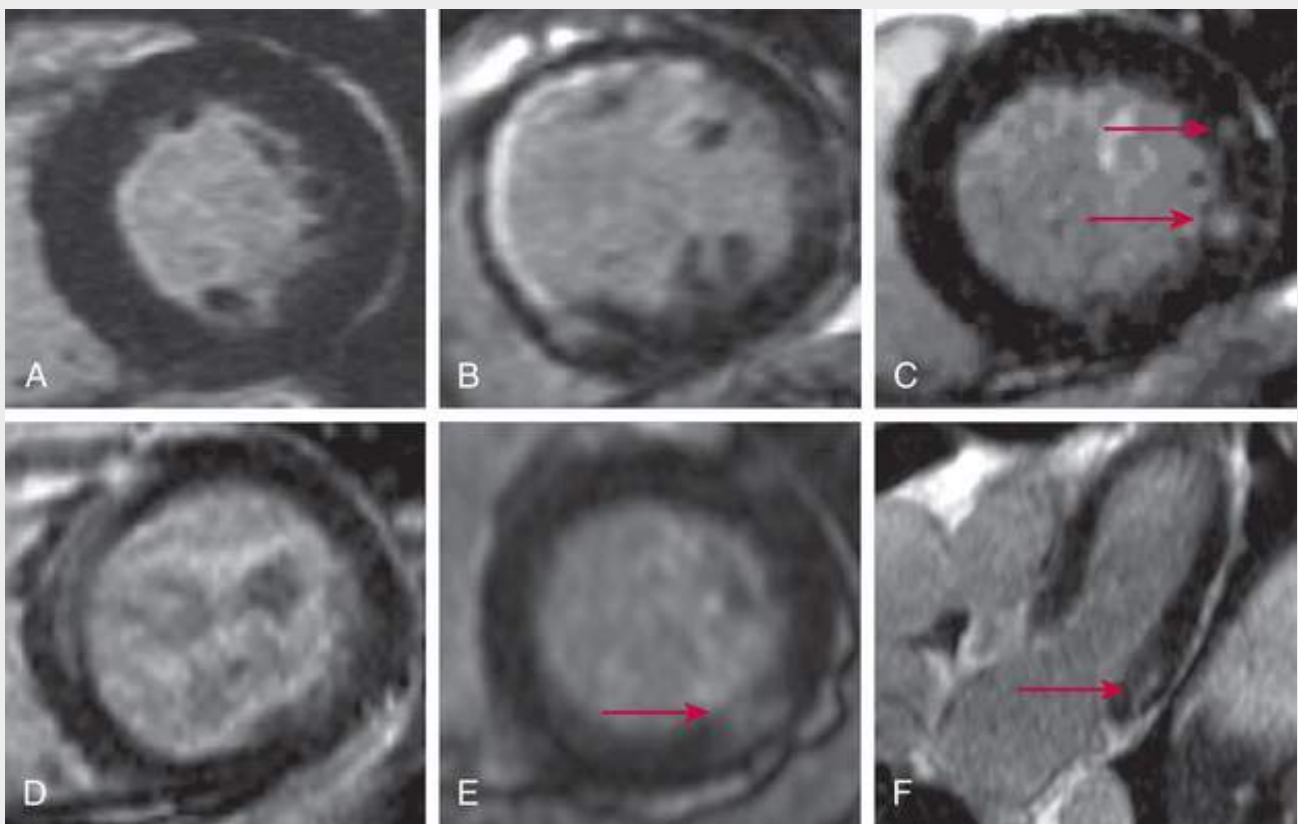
Cardiac magnetic resonance images showing different patterns of late gadolinium enhancement (LGE) observed in patients with aortic stenosis. A, No LGE. B, Infarct LGE with subendocardial pattern observed in septum and anterior wall. C, Two focal areas of midwall LGE in lateral wall of left ventricle (*red arrows*). D, Midwall LGE in a more linear pattern, affecting the septum. E, Short-axis view, and F, long-axis view, of midwall LGE (*red arrows*) of the inferolateral wall in the same patient. (Dweck MR, Joshi S, Murigu T, et al. Midwall fibrosis is an independent predictor of mortality in patients with aortic stenosis. *J Am Coll Cardiol* 2011;58:1271-9.)
